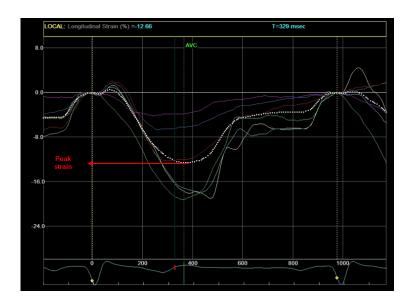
6 Longitudinal strain curves from the apical 4-chamber view
